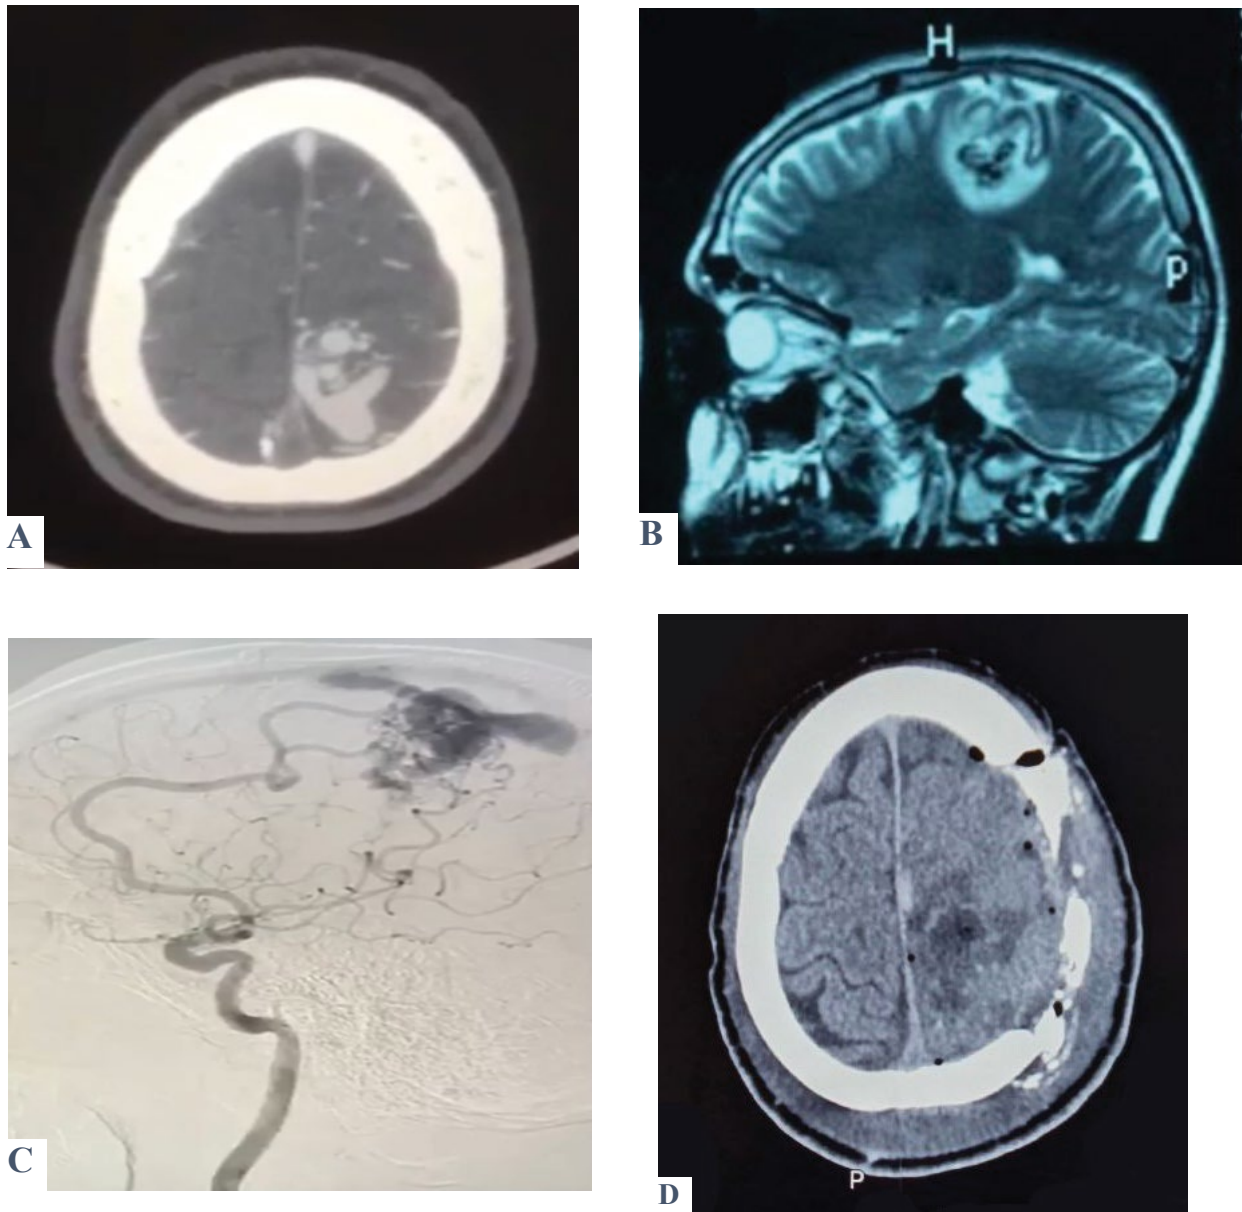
Shows a case of a 30-year-old male presented with two attacks of seizures associated with recurrent episodes of nausea and vomiting. On examination, there was no motor or sensory deficit, Glasgow coma score (GCS) was 15 with no fit or vomiting. A brain CT scan (A) was ordered and showed a left parietal AVM confirmed by MRA (B). DSA was performed to reveal exactly the location and characteristics of the feeding arteries and draining veins (C). Post-operatively, the patient's GCS was 15 with no fit and only one episode of vomiting. Motor examination revealed a decrease in the initiation of movement; otherwise, the patient was improved. Post-operative CT was done and showed total excision of the AVM (D).
